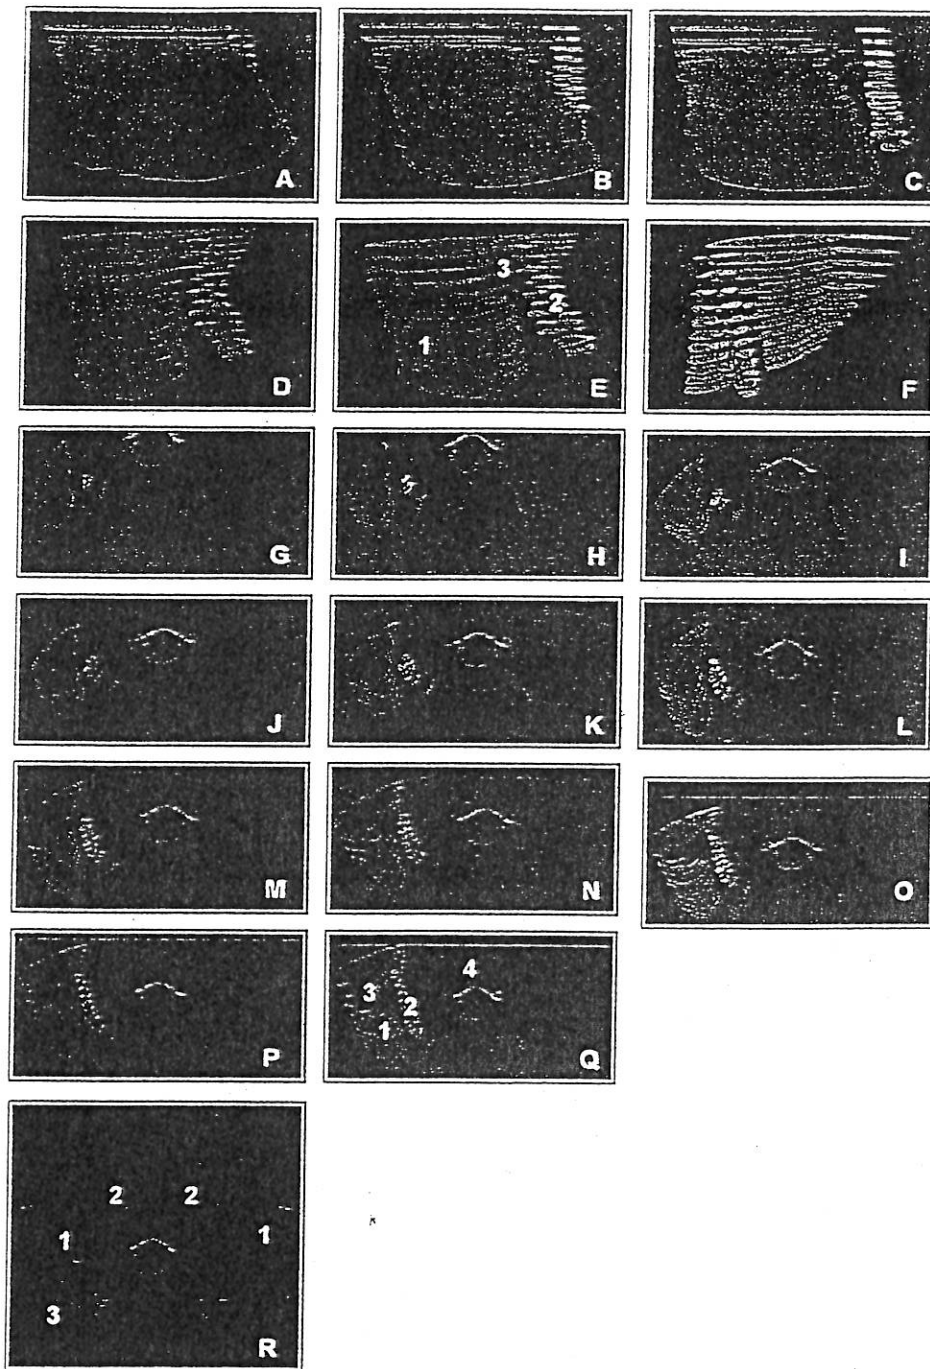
A-F) model obtained by point sampling of m. sternocleidomastoideus (1), carotid artery (2), internal jugular v. (3): views obtained rotating the model from medialis to frontal position; G-Q) model obtained by point sampling of m. sternocleidomastoideus (1), carotid artery (2), internal jugular v. (3): comparison with the CT scan image of the section 1629 of V. H. D. (4). R) Reconstruction of carotid (1) and vertebral (2) arteries; comparison with the CT scan image of the section 1629 of V. H. D. (3).
